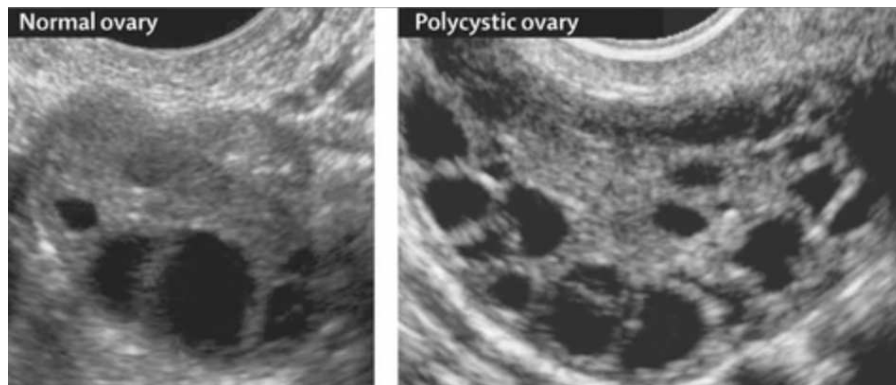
Comparative ultrasound of an ovary without PCOS and with PCOS. Source: Alice Monney, (2022).
